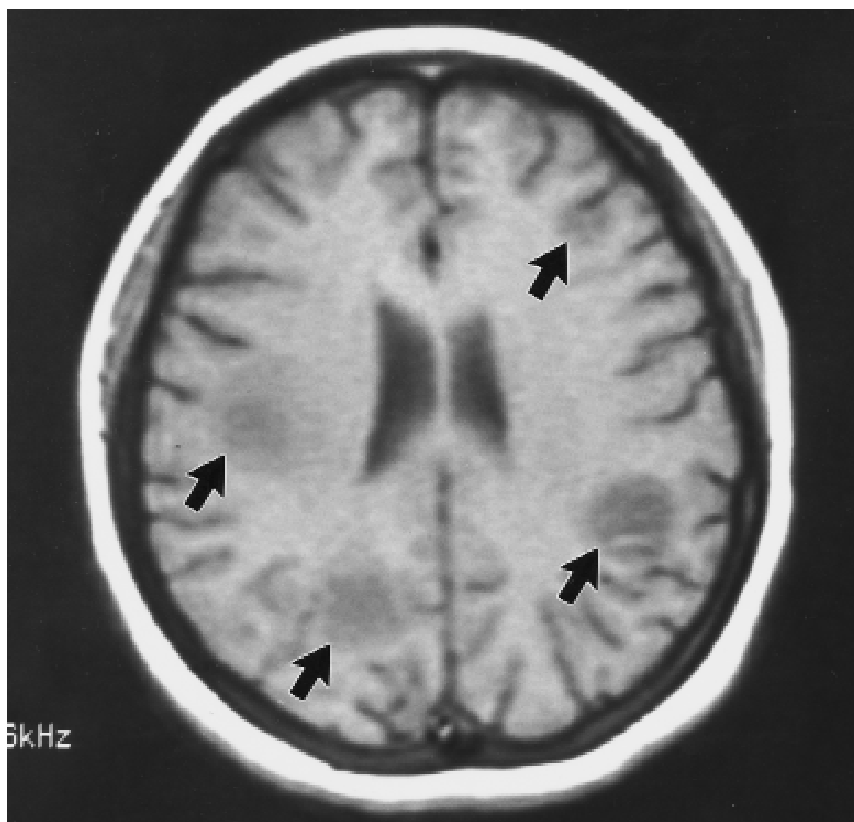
Proton-density weighted MRI scan from hospital day 15 showing bilateral, rounded, hypodense lesions of various sizes in the deep white matter (arrows).
